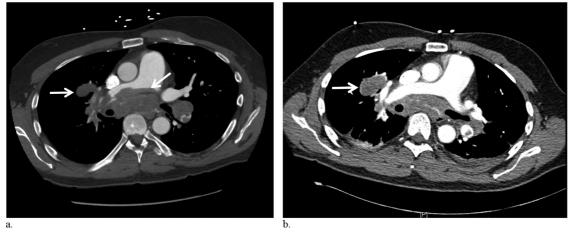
(a) Case 1. CT angiogram depicting submassive saddle embolus (arrow, right) with additional filling defects in right segmental branches (arrow, left). (b) CT angiogram depicts reduced thrombus burden after thrombectomy; clot is still present in right segmental branches (arrow).
